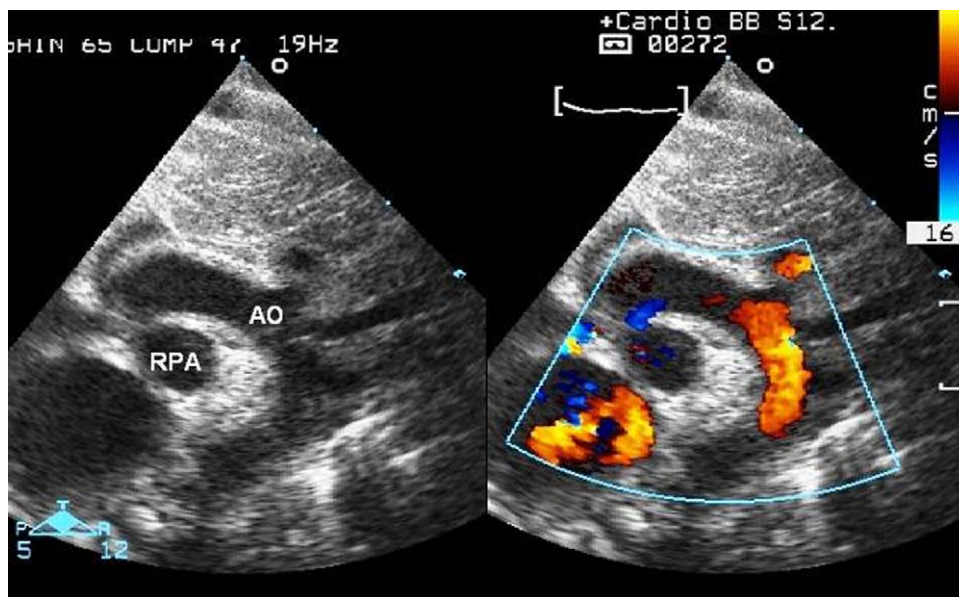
Suprasternal view without (left) and with colour Doppler (right). The right pulmonary artery arises from the posterior wall of the aorta. The colour Doppler scan shows a diastolic reflux from the aortic arch going to the right pulmonary artery. Ao: aorta; RPA: right pulmonary artery(Supplementary data).
